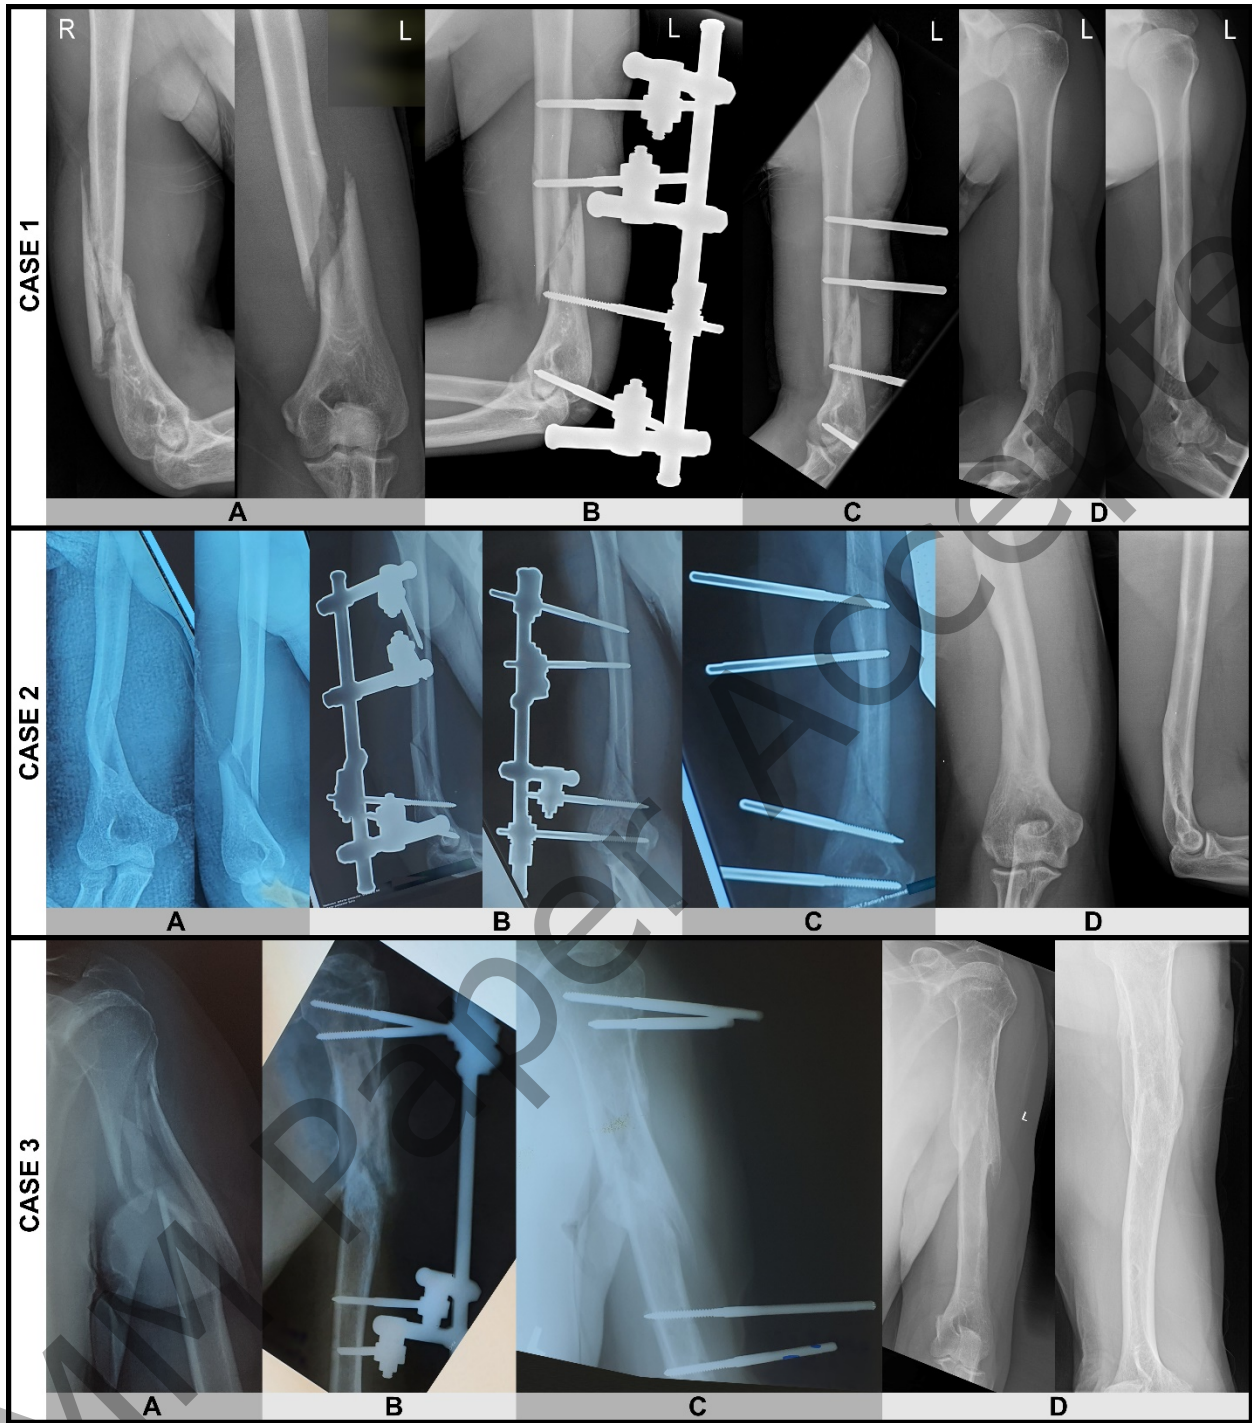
X-rays of the cases on the day of injury (A), about one week after surgery (B), on the day of pins removal (C), and three years after external fixation (D).
